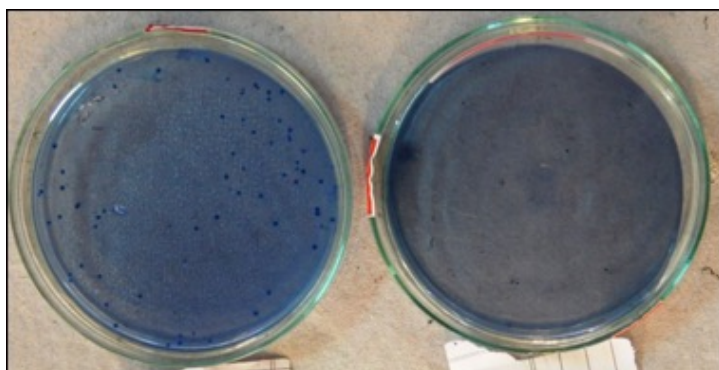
Group a Ultrasonic pre and post treatment dentin samples cultured plates showing S. Mutans colonies
